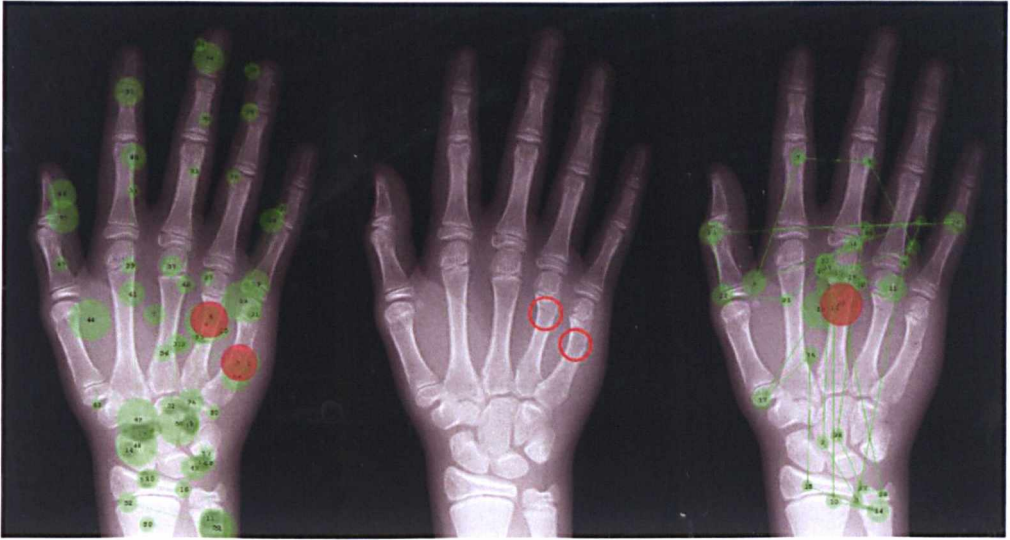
Fixation plots of a consultant orthopaedic surgeon (left) and an orthopaedic senior house officer (right) viewing a hand radiograph with two fractures (circled red, centre). In these plots, the green circles are fixations (the larger the longer the fixation) and green lines are saccades, red circles indicate fixations when the button was pressed. This shows that the senior house officer missed the two fractures, and misdiagnosed the growth plate (third metacarpal) as a fracture. Furthermore, this subject did an incomplete survey of all the bones in the hand radiograph.
